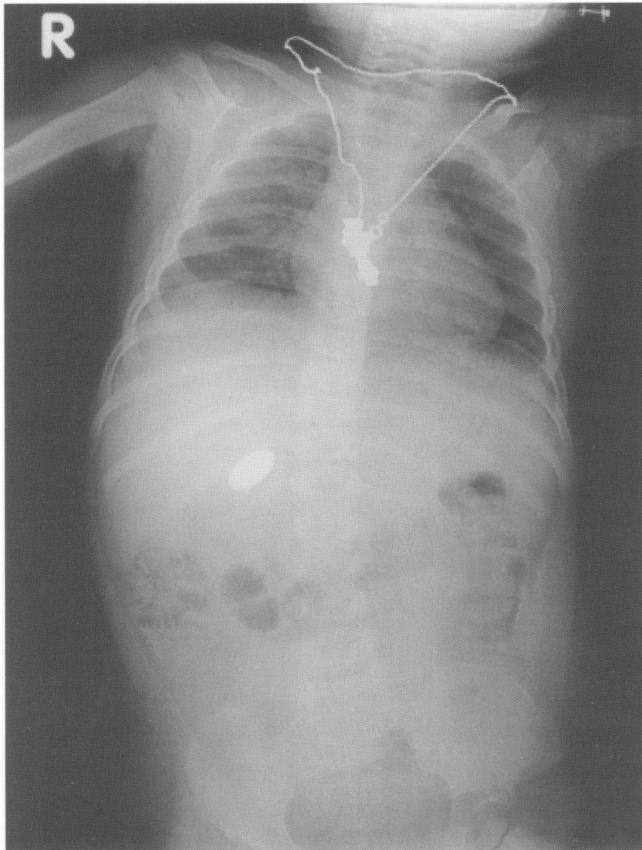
Thoraco-abdominal radiograph demonstrating a coin within the first part of the duodenum.
